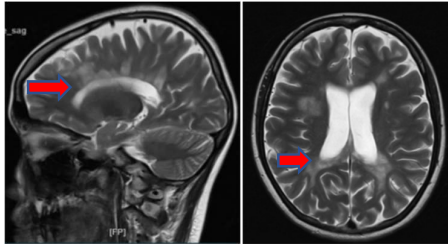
MRI images of the axial and sagittal T2W1 head showed multiple lesions in the left and right lateral periventricular and Dawson's Finger images that supported a Multiple Sclerosis picture
